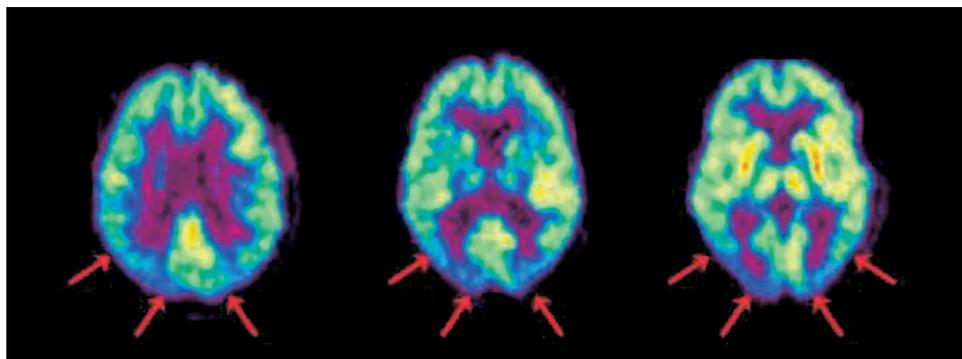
Dementia with Lewy bodies. FDG-PET pattern is typically posterior-predominant, as in AD, but without preferential sparing of occipital cortex.
